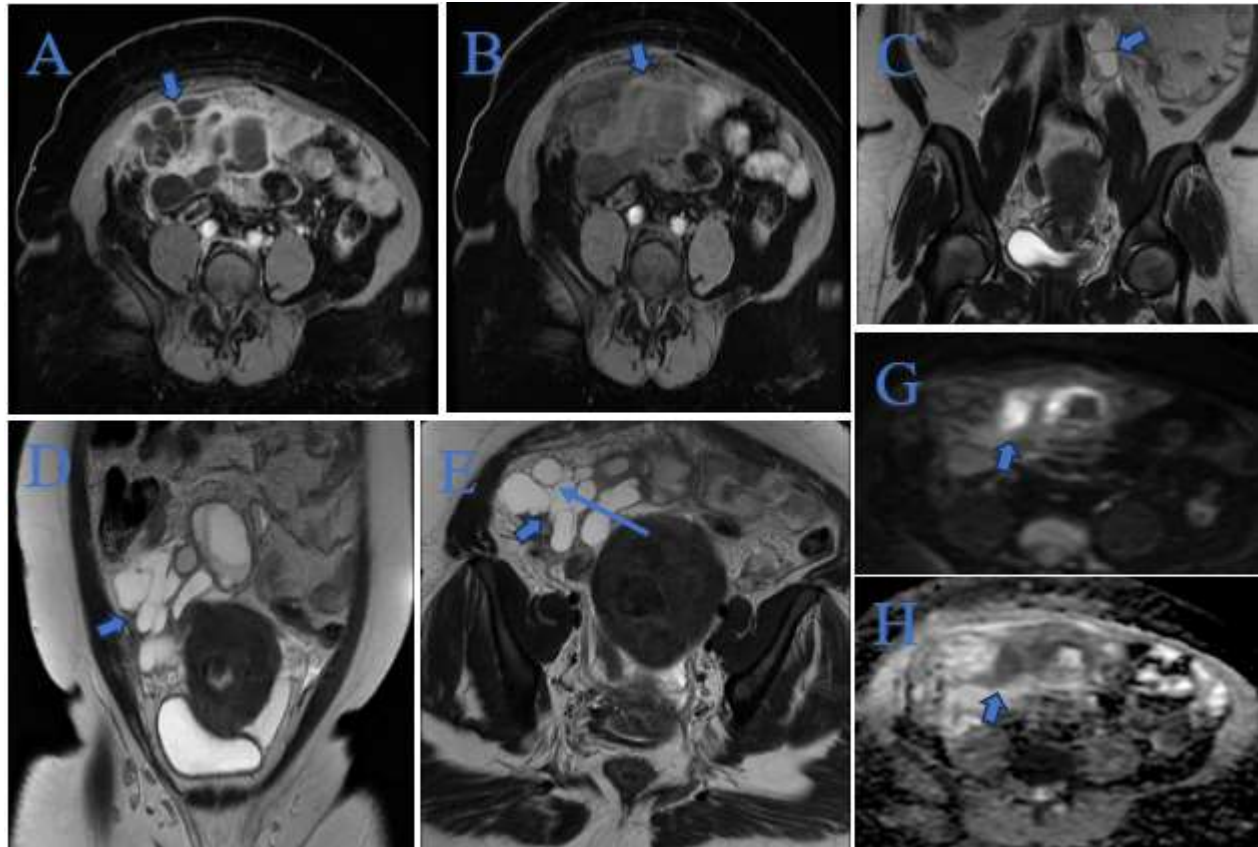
Magnetic Resonance Imaging (MRI) images. (A) Axial T1WI post contrast venous phase showing a large multilocular cystic mass with thick enhancement of the walls and septations with irregular margins (solid short arrow). (B) Axial T1WI without IV contrast showing hyperintense walls of the cystic mass (solid short arrow). (C) Coronal T2WI showing cystic lesions in the left para-aortic region correspond to previously seen para-aortic lymph nodes (solid short arrow). (D) Coronal and (E) Axial T2WI showing complex multilocular cystic mass and some of the locules interconnected to each other forming tubular structures with variable signal intensity of these locules (solid short arrow) and significant surrounding inflammatory changes with edema manifested by hyperintense signals of the surrounding fat (solid long arrow). (G) Axial DWI showing region of high signal intensity which demonstrates diffusion restriction in ADC image (H).
